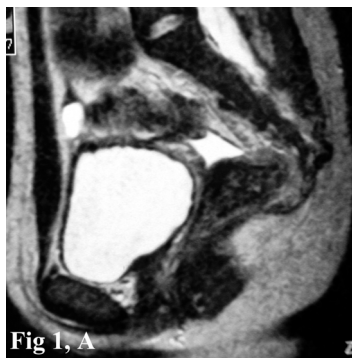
Vaginal atresia in a 17-year-old girl with primary amenorrhea and cyclic pelvic pain. A. Sagittal T2-weighted fast SE image (TR/TE, 4500/120) demonstrated the uterine cavity and cervical canal were distending with blood (hematometra). The upper portion of the vagina was also dilated and filled with blood (hematocolpos), and ended blindly owing to the presence of a vaginal atresia. B. Axial T1-weighted SE image (TR/TE, 500/15) showed hematometra and right-sided endometrioma
